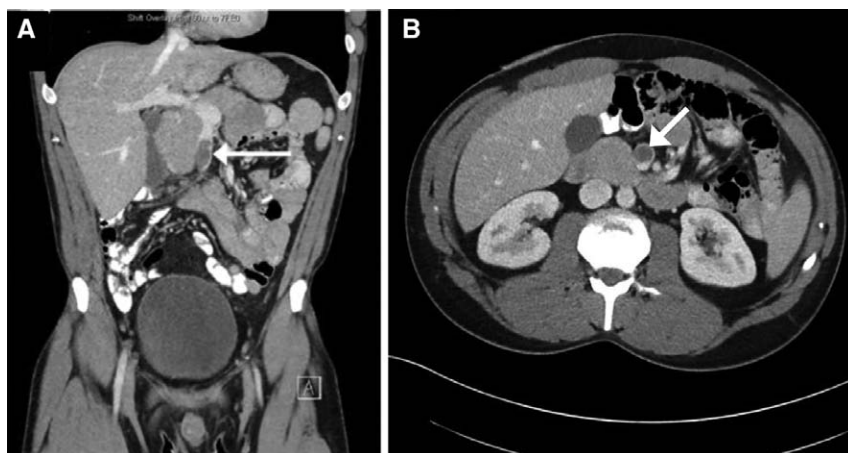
Computed tomography (CT) of the abdomen, coronal view, documenting thrombus in the superior mesenteric vein (white arrow; A). Axial view on CT confirms superior mesenteric vein thrombosis (white arrow; B).
